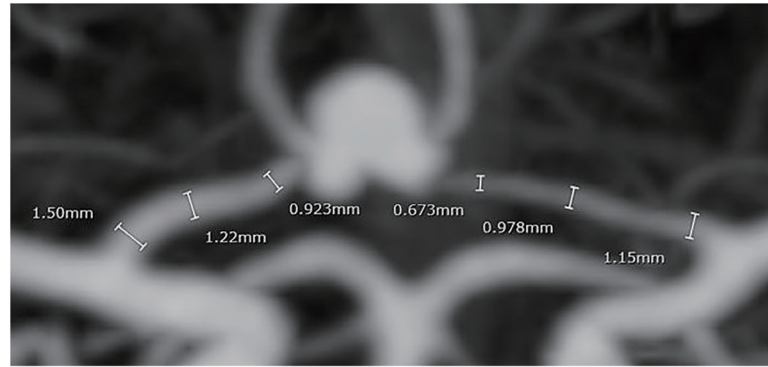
Calculation of A1 diameter. The diameters of ipsilateral (iA1) and contralateral (cA1) segments and their ratios were measured at the initial, middle, and terminal points of the bilateral A1 segments in the anteroposterior view on the initial 3D CT angiograms. The A1 segment diameter was calculated as the average of 3 measurements.
